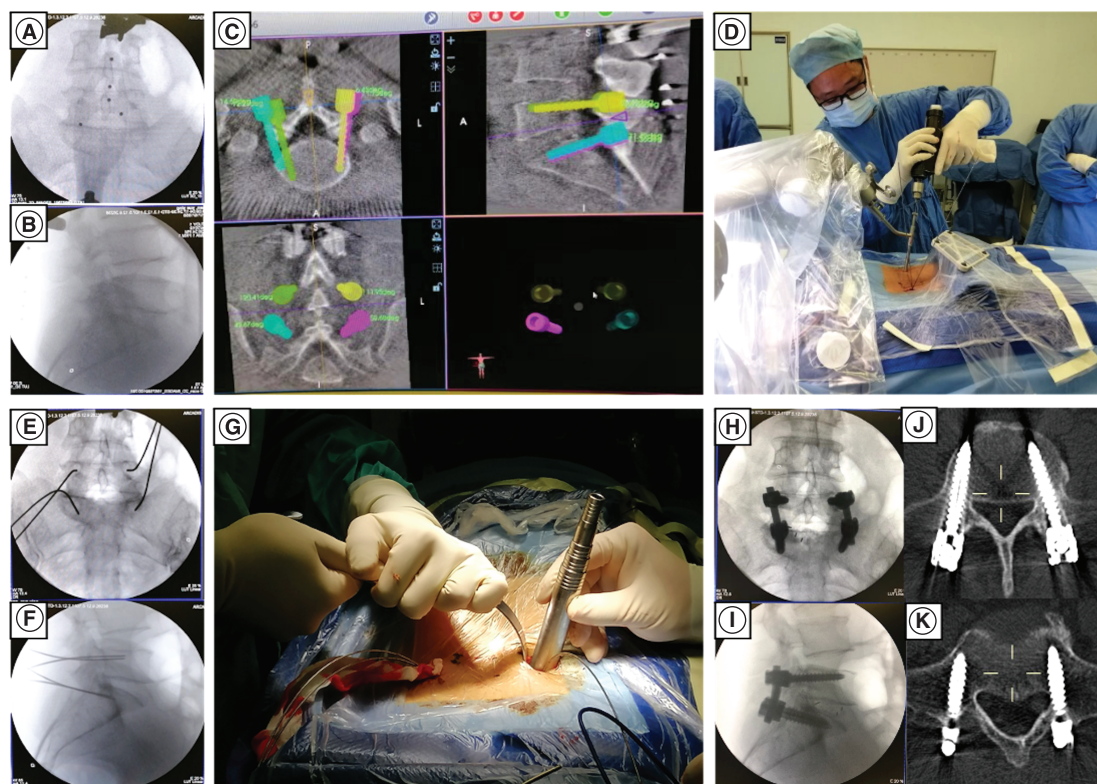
The general steps of robot-assisted minimally invasive transforaminal lumbar interbody fusion surgery. Registration (A–B); trajectory planning (C); automatic location and manual K-wire insertion (D); confirmation of K-wire position (E–F); performance of minimally invasive transforaminal lumbar interbody fusion procedure (G); fluoroscopy for screw position verification (H–I); evaluation of screw grade by postoperative computed tomography scan (J–K).
